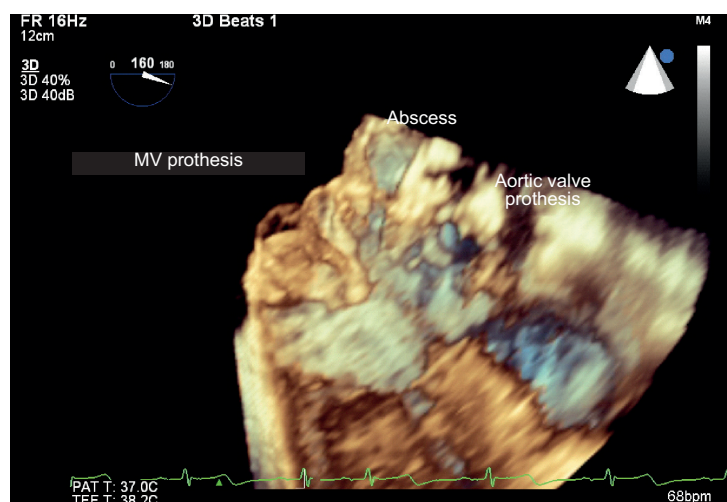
Three-dimensional transesophageal echocardiogram showing aortic periprosthetic neocavity extending to the mitroaortic junction.
